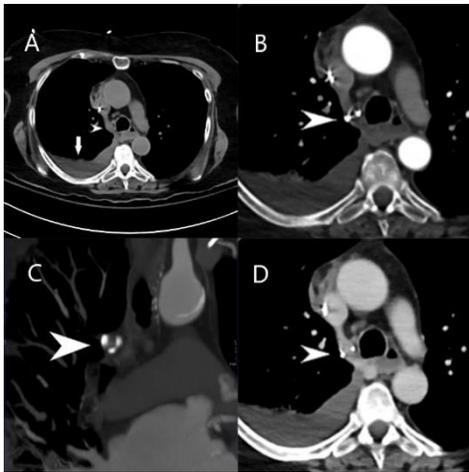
CT-Angiogram of the case.
